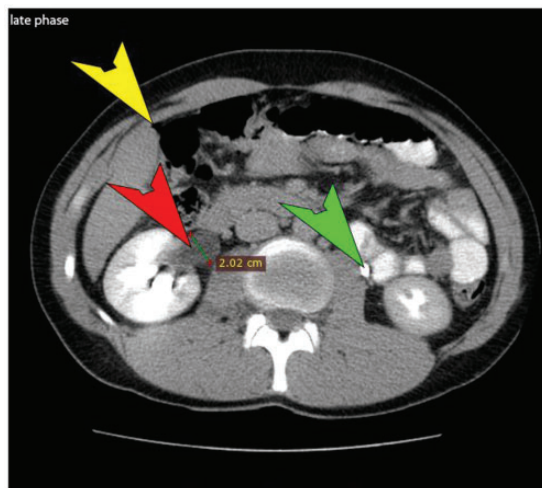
Computed tomography. Under the liver, a small amount of free abdominal air can be observed (yellow arrowhead). Ureteral dilation is present on the right. The late phase image shows that the contrast medium is not excreted into the right pylon, still, nephrographic effect is visible (red arrowhead). On the left side, the kidney's morphology is physiological, and contrast excretion is present in the ureter (green arrowhead).
